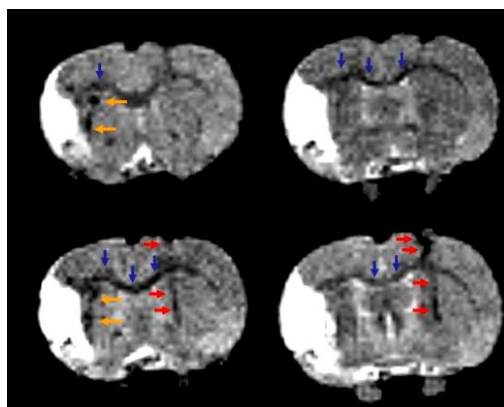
shows that GRID-labeled neural stem cells can still be detected by MRI 4 weeks after transplantation. Some cells still line the injection tract (red arrows), but others appear to migrate or reside in the corpus callosum (blue arrows). A large number of cells appear to reside in the peri-infarct area, but do not appear to form the border of the infarct area at this time point (orange arrows).
